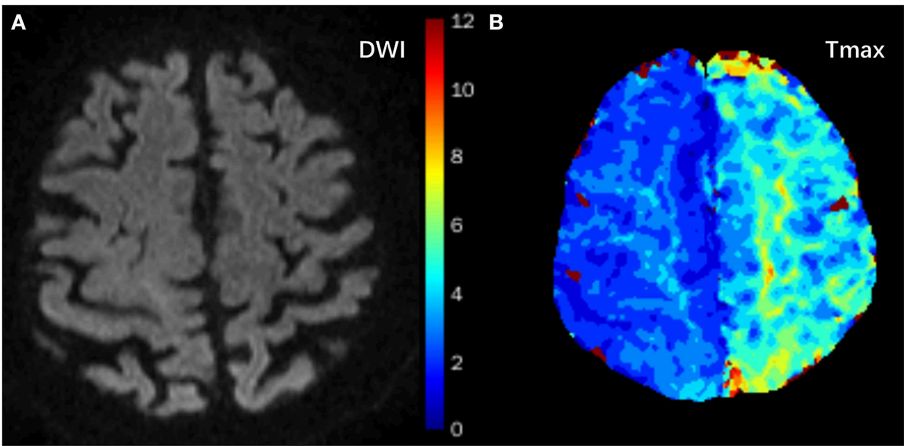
Typical images of an 84-year old female with a history of hypertension who presented with right upper limb paresis three times within 4 h. It lasted 2 min each time. DWI showed negative findings of strokes (A), but *T*_{max} showed focal hypoperfusion areas in the left frontal and parietal lobes (B, green areas).
